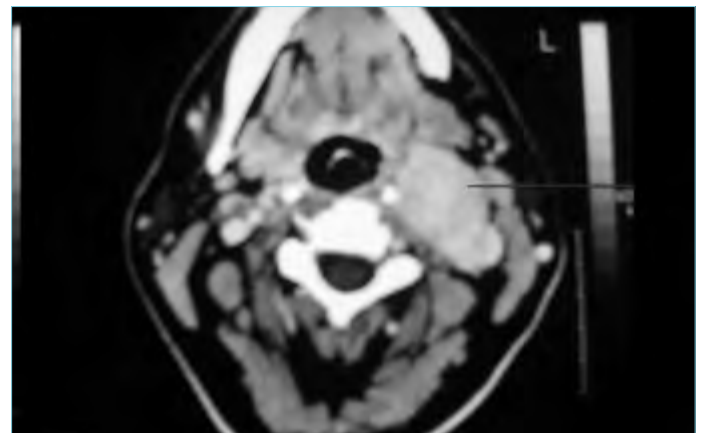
Imaging of carotid body tumor on computed tomography
